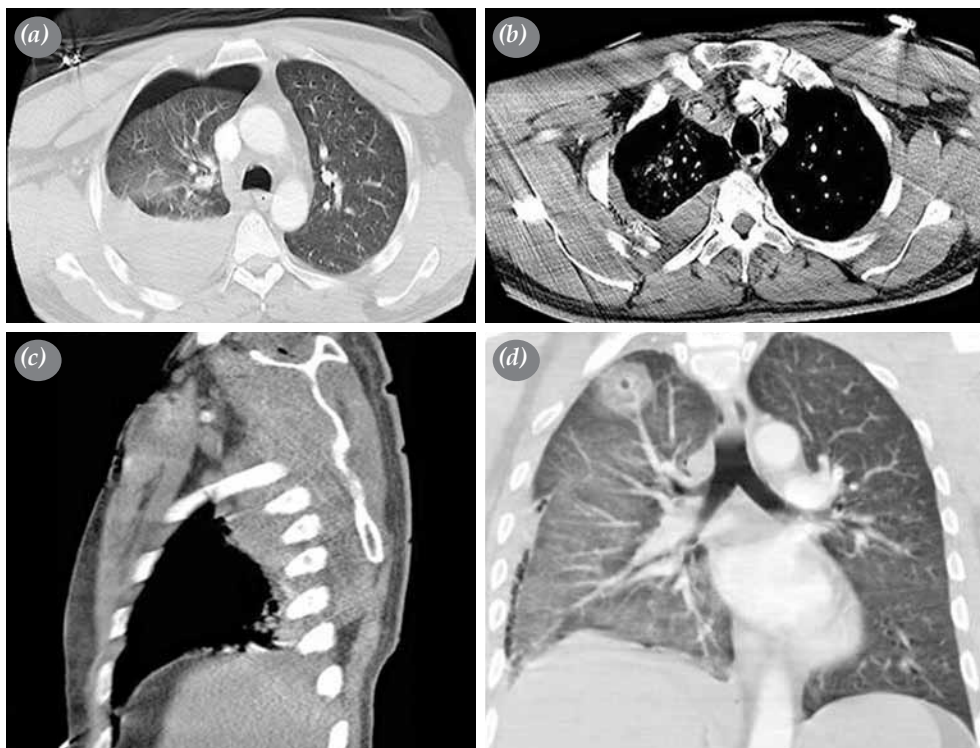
Computed tomography of chest. (a) Right hemopneumothorax, (b) fracture at third rib, (c) scapular fracture, (d) possible trajectory of bullet at upper lobe.
